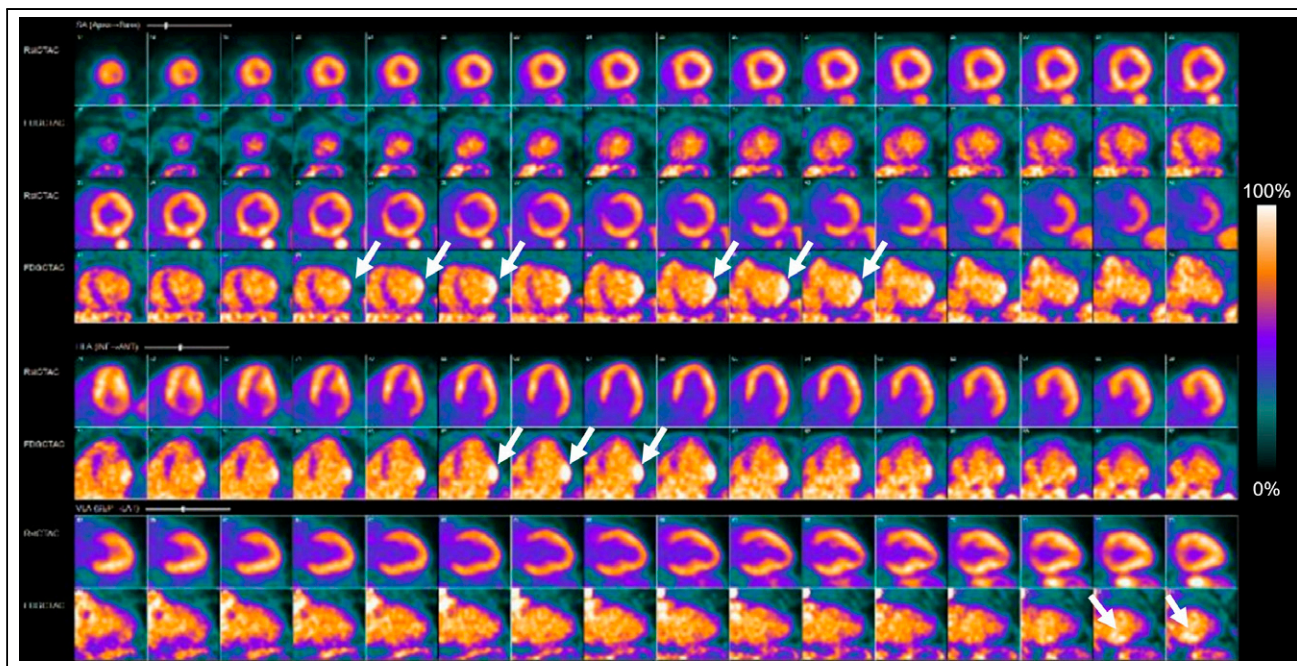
Scan 2 ^{82}Rb -chloride rest perfusion (top rows) and ^{18}F -FDG cardiac metabolism (bottom rows). Images show diagnostic evaluation with ^{18}F -FDG blood-pool activity indicating adequate dietary preparation. Rest images show borderline hypoperfusion in basal to mid inferolateral wall and moderate LV enlargement. Rest gated images showed 31% LVEF. ^{18}F -FDG images show suspected early-to-progressive stable cardiac sarcoidosis with moderate inflammatory ^{18}F -FDG uptake in basal to mid inferolateral wall (arrows).
